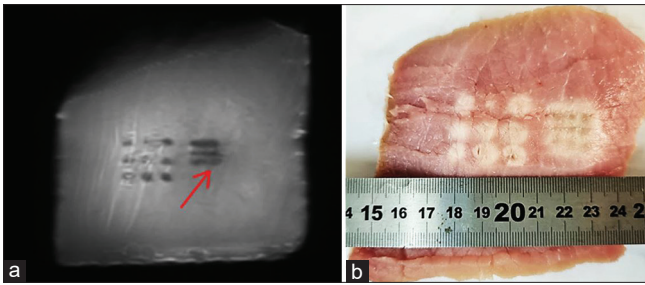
(a) 2D coronal T2-weighted fast spin echo image (repetition time = 2500 ms, echo time = 48 ms, flip angle = 180°, echo train length = 60, PB = 50 Hz/pixel, matrix size = 256 × 256, and field of view = 200 mm × 200 mm × 10 mm) acquired after sonication in a 3 × 3 grid (acoustic power of 60 W for 40 s) with a spatial step of 5 mm (time delay of 60 s) in the 3 T magnetic resonance imaging scanner. The red arrow indicates the formed overlapping lesion. The discrete lesion created with the 10-mm step is also visible on the left side. (b) Photo of the tissue sample cut horizontally at 10 mm from the sonicated surface
